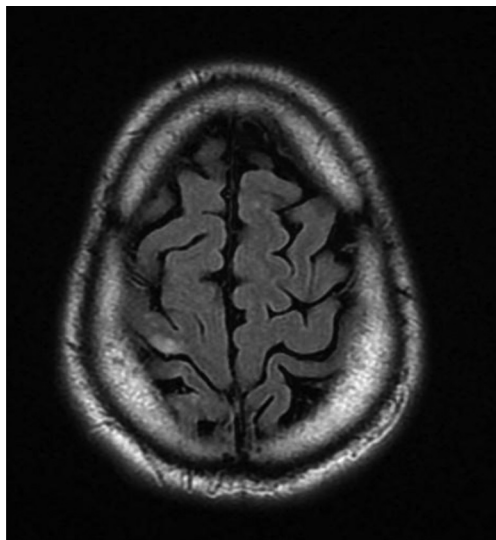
Axial diffusion-weighted MRI imaging demonstrating acute ischemic infarction of the primary motor cortex.
